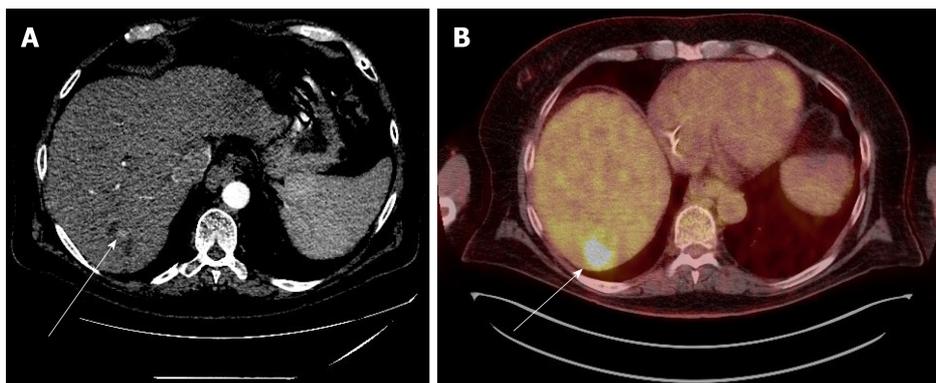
Case 2. A: Multi-phase computed tomography scan: a hypodense area, indicated by the white arrow, in the liver during the arterial phase post trans-arterial chemo-embolization treatment; B: Positron emission tomography scan: in the same area, there is avid fludeoxyglucose uptake, indicating residual tumor.
